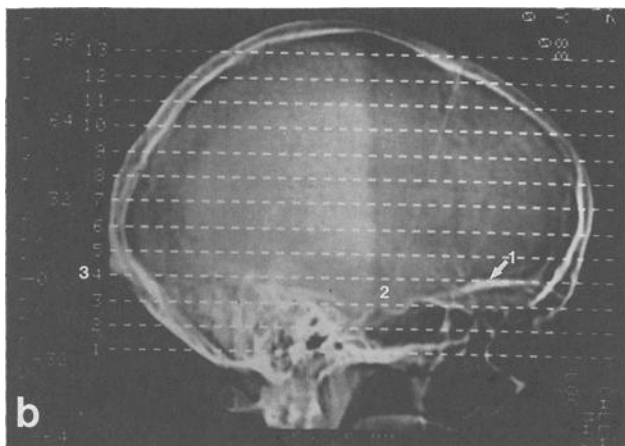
Antemortem scout view, taken at time of CT scan.
